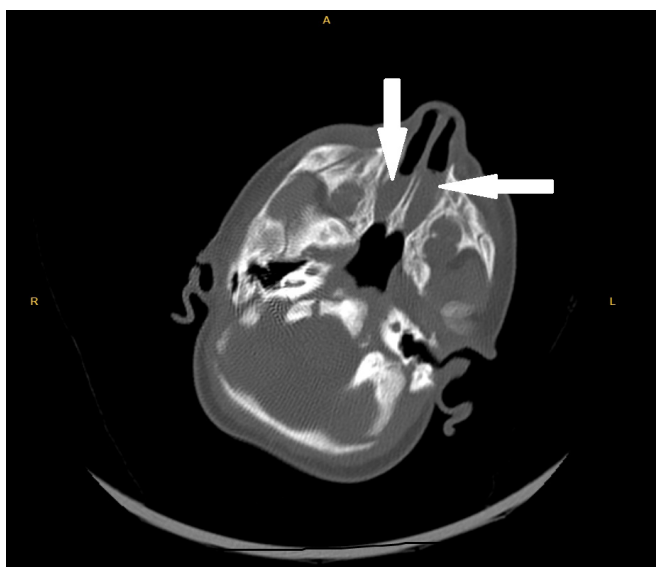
Axial CT scan showing soft tissues causing obstruction of airway by fully occluding nasal passage in both sides (arrows).*
